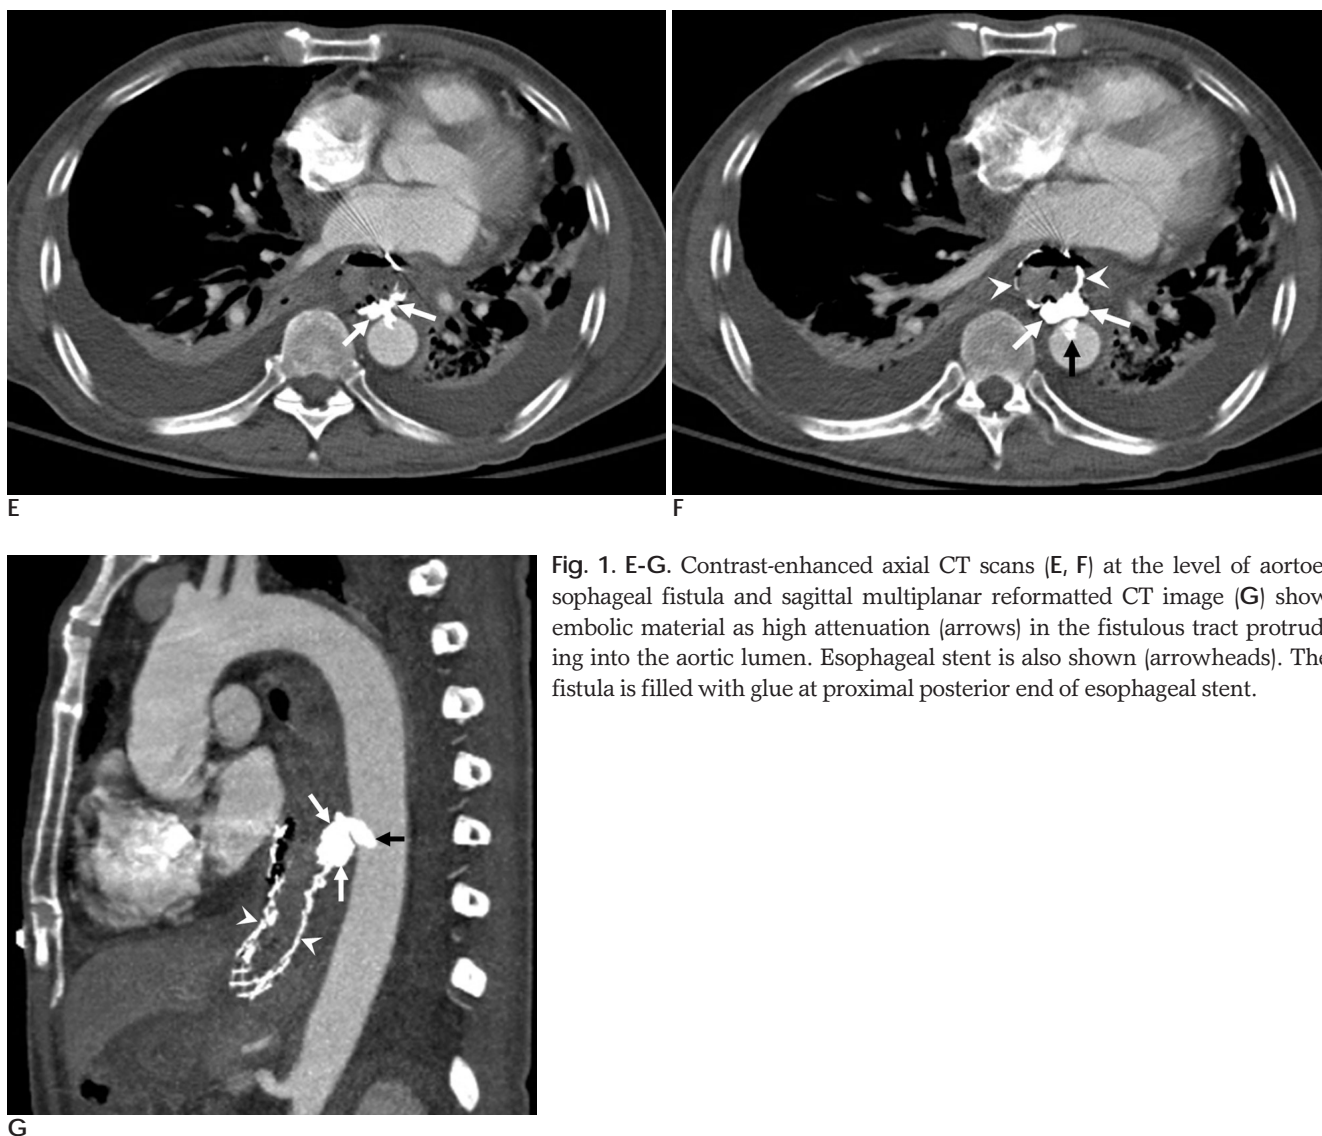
E-G. Contrast-enhanced axial CT scans (E, F) at the level of aortoesophageal fistula and sagittal multiplanar reformatted CT image (G) show embolic material as high attenuation (arrows) in the fistulous tract protruding into the aortic lumen. Esophageal stent is also shown (arrowheads). The fistula is filled with glue at proximal posterior end of esophageal stent.
